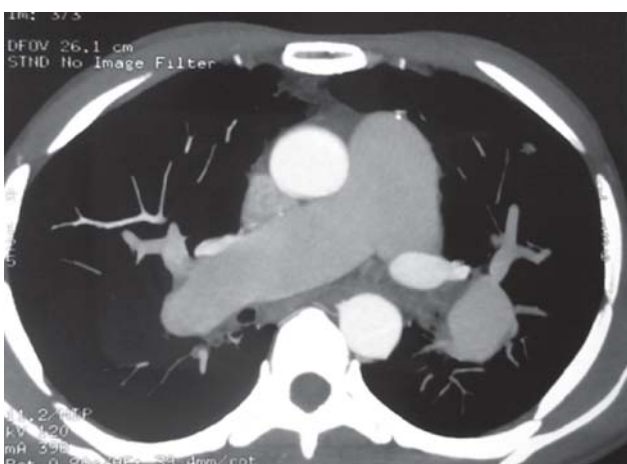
Contrast-enhanced computed tomography of thorax (axial view) showing grossly dilated pulmonary trunk and arteries as comparison to other mediastinal structures which suggestive of pulmonary hypertension.
